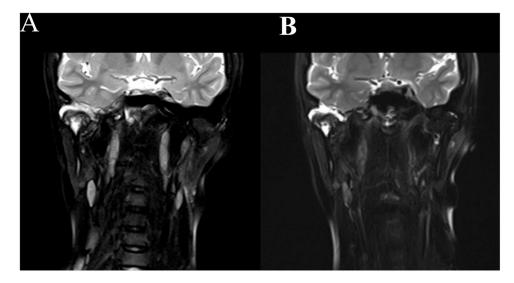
Magnetic resonance imaging study (T2 study), A. Fourteen month before admission, B. On the seventh day of admission, Right-to-front skull base was destructed with osteolysis and cerebrospinal fluid leakage was observed.
